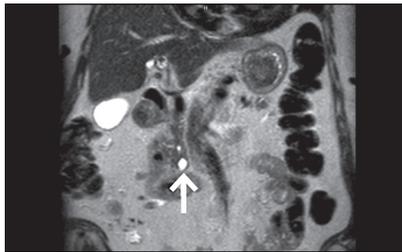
Coronal T2-weighted magnetic resonance image demonstrating the same 1.2-cm pancreatic cyst.
